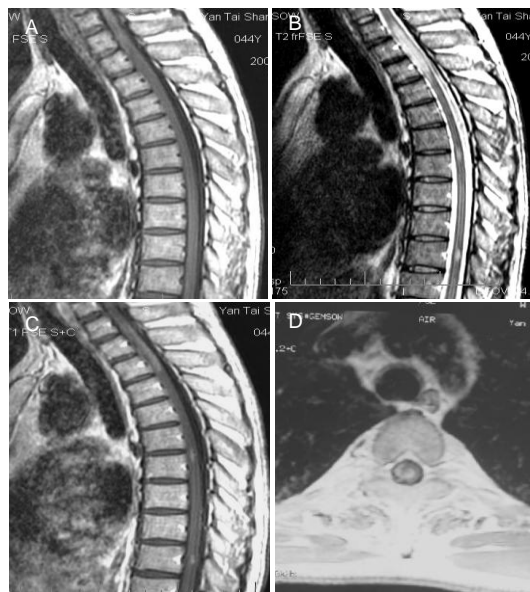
Magnetic resonance imaging results of thoracic spinal cord of a 44-year-old male patient with tumor-like inflammatory demyelinating disease, who complained of lower extremity weakness with zonesthesia on the chest and back for 2 months.
